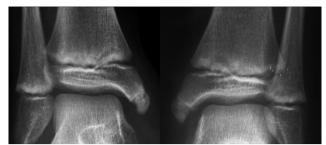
AP radiographs of both ankles.
